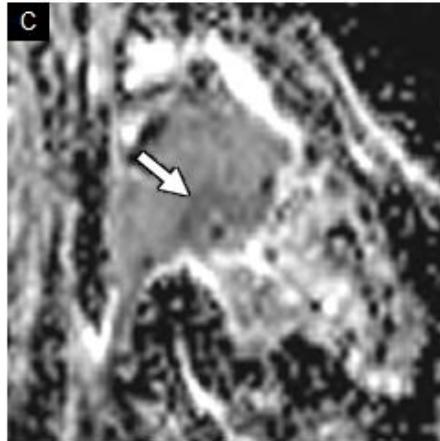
72-year-old woodworker with T3N2cM0 high grade squamous cell carcinoma of the right nasal cavity. Axial CECT (A) shows a soft tissue mass (white arrows) centered within the right nasal cavity with extension into the superior right maxillary sinus (white arrowhead). Axial T1WI C+ FS MRI (B) demonstrates heterogeneous enhancement of the mass (white arrows), which enhances much less avidly than the normal sinonasal mucosa (white arrowhead). On axial T2WI FS MRI (C) and axial ADC map (D), the mass is hypointense (white arrows), indicative of a high cellularity tumor. Axial 18F-FDG PET/CT (E) shows markedly high FDG avidity of the right nasal cavity mass (black arrows).
